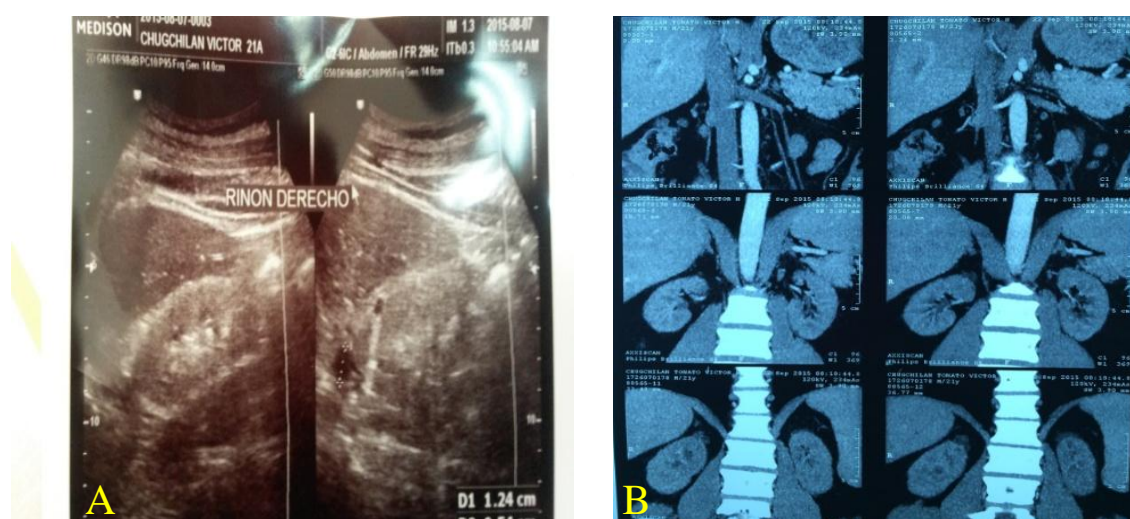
(A) Renal ultrasound: reduction in the corticomedullar relationship, (B) renal tomography: simple cysts
